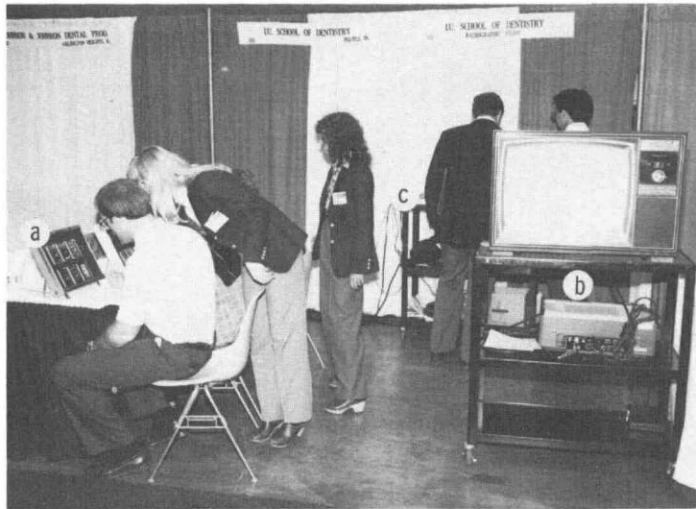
An exhibition booth at a dental society meeting, with three of the investigators (E.C., W.S., and P.Y.) assisting dentists in answering the questionnaire relative to the radiographs taped on (a) the viewing boxes to eliminate extraneous light, (b) the videotape instrumentation for instructing the dentist in the procedures of the questionnaire, and (c) the location of the electronic enhancement instrumentation. Below, the coded Ektaspeed® film (l) and the uncoded xeroradiograph film with the image of the x-ray resolution paired line test pattern at (d) and the density step wedge at (e).
